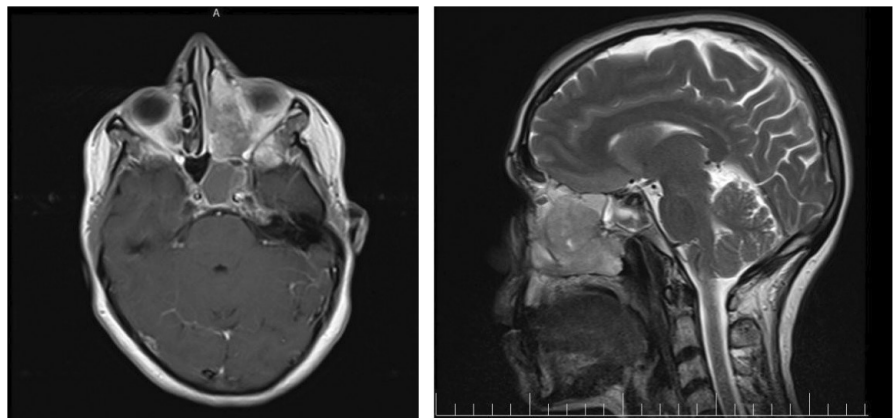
Pretreatment MRI (soft tissue mass in the ethmoidal sinus, nasal cavity, and maxillary sinus).
